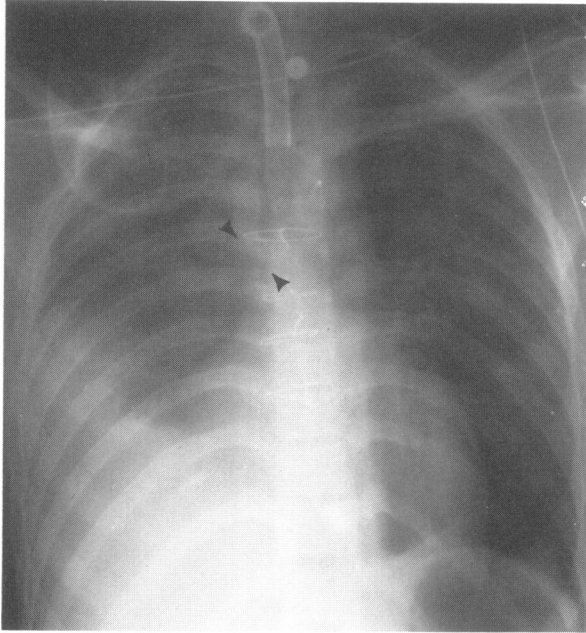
This 27-year-old man was brought to the Emergency Room after an automobile slipped off a jack onto his thorax. He had decreased breath sounds on the right. The radiograph at that time reveals tension pneumothorax with a moderate amount of air in the pleural space, shift of the mediastinal structures to the left and depression of the right hemidiaphragm (Figure 3a). Follow-up radiographs two weeks later revealed increasing opacification of the right hemithorax (Figure 3b). The discontinuity of the right main-stem bronchus (black arrowheads) demonstrates the site of the bronchial rupture.
